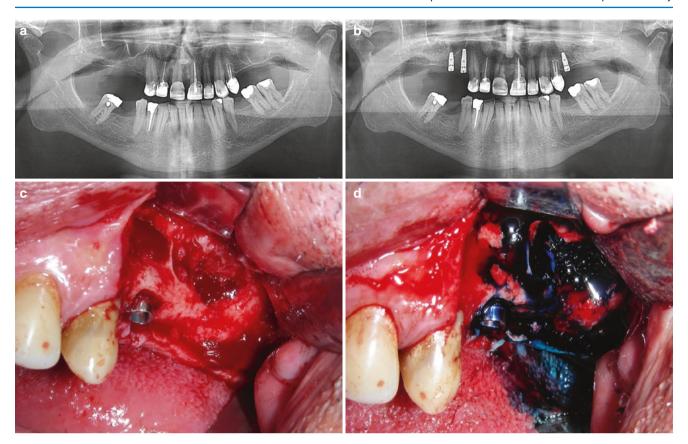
Sinus floor augmentation failure. (a) Preoperative OPG of the patient candidate for implant dental rehabilitation of edentulous regions comprising implant placement and SFE procedures on both sides of the upper jaw. (b) Postoperative OPG showing three implants in place and graft material at the sinus floor. (c) Intraoperative view of the left side showing the graft failure. (d) The wound is debrided and the bone and the soft tissues treated with photodynamic principle. (e) The DBBM granules and ABP are ready to be used for re-grafting. (f) Grafts in place, the OCG is used to isolate the Schneiderian membrane perforation, and the distal implant is inserted and DBBM granules placed over the mixture to prevent the resorption. (g) Wound closure. (h) Postoperative OPG showing new implants in place (arrow). (i) Clinical photograph of the healing abutments in situ. (j) OPG of the patient candidate for extensive prosthetic and implant treatment. SFE had been performed on the right side. The arrow points to the left maxillary sinus prior to SFE. (k) Postoperative OPG showing the graft in place (arrow). (I) OPG taken after implant placement. (m) OPG showing the situation after completion of implant and prosthetic rehabilitation. (n) Dental radiography taken 5 years after the completion of the treatment. The patient is referred by her physician to examine possible causes of her allergy affecting the head and neck resulting in severe migrating oedemas. The present radiography does not reveal pathological findings. (o) The patient has been advised by her doctor to have the CT scan undertaken showing overcontoured alveolar ridge on the left side that has
